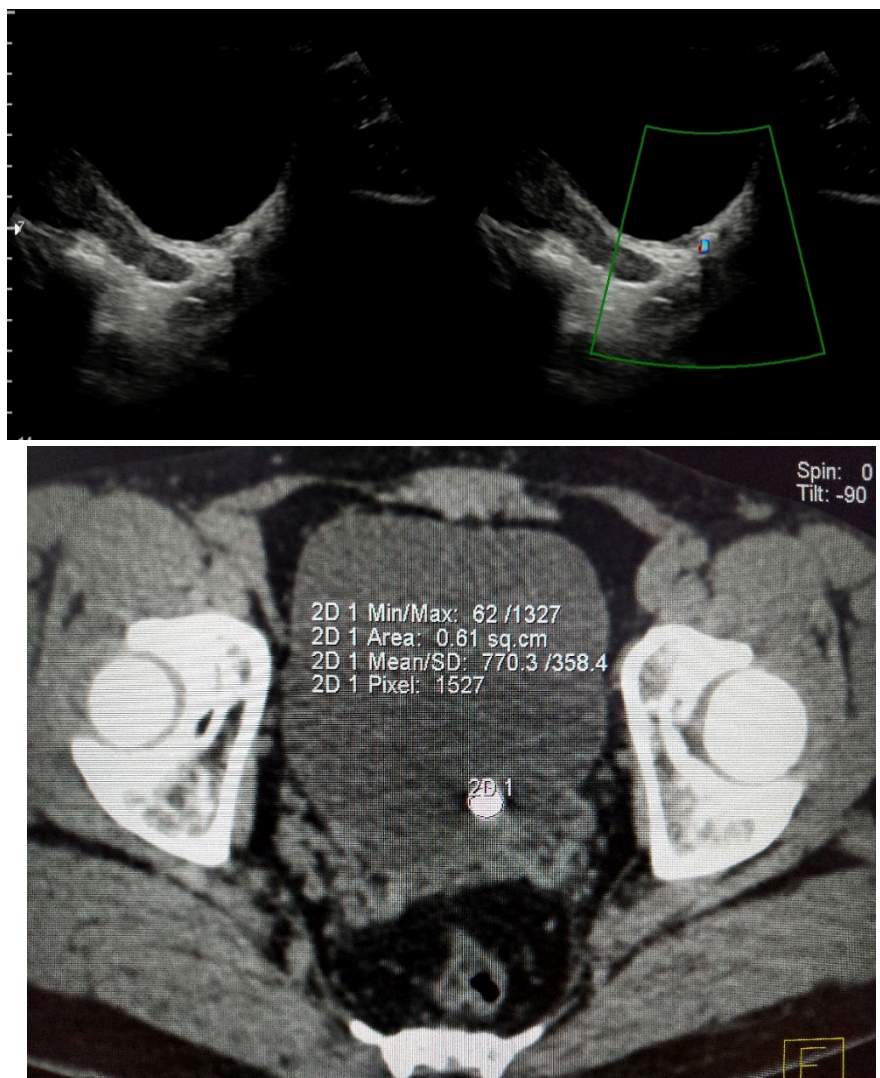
Figure II (A, B): US (grey scale and colour doppler) showing calculus in the distal left ureter with grade 1 twinkling artifact. Same patient CT performed one day later showed calculus in left vesico-ureteric junction with mean HU of 770.
